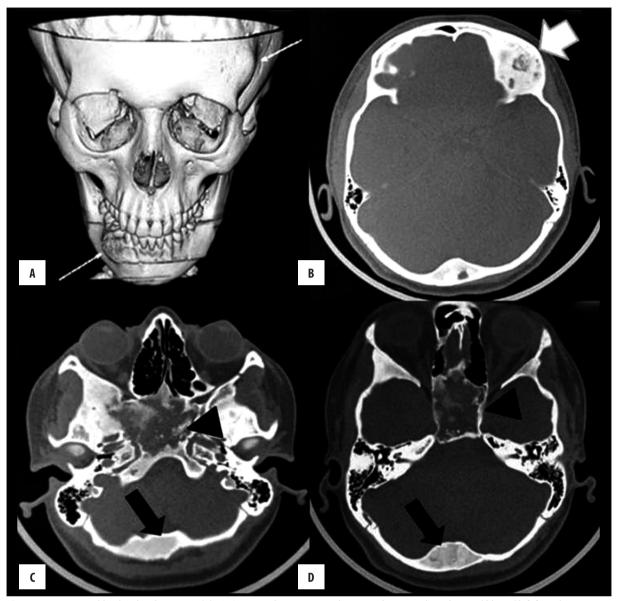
A 14-year-old girl with polystotic FD. (A) 3D-CT image showing expansile osseous lesions in the right mandible and left frontal regions (thin white arrow), and (B–D) unenhanced axial CT images on bone window demonstrating a mixed pattern in the right frontal bone (white arrow), lytic pattern in the sphenoid region (black arrowhead), and sclerotic pattern in the occipital bone (black arrow).
